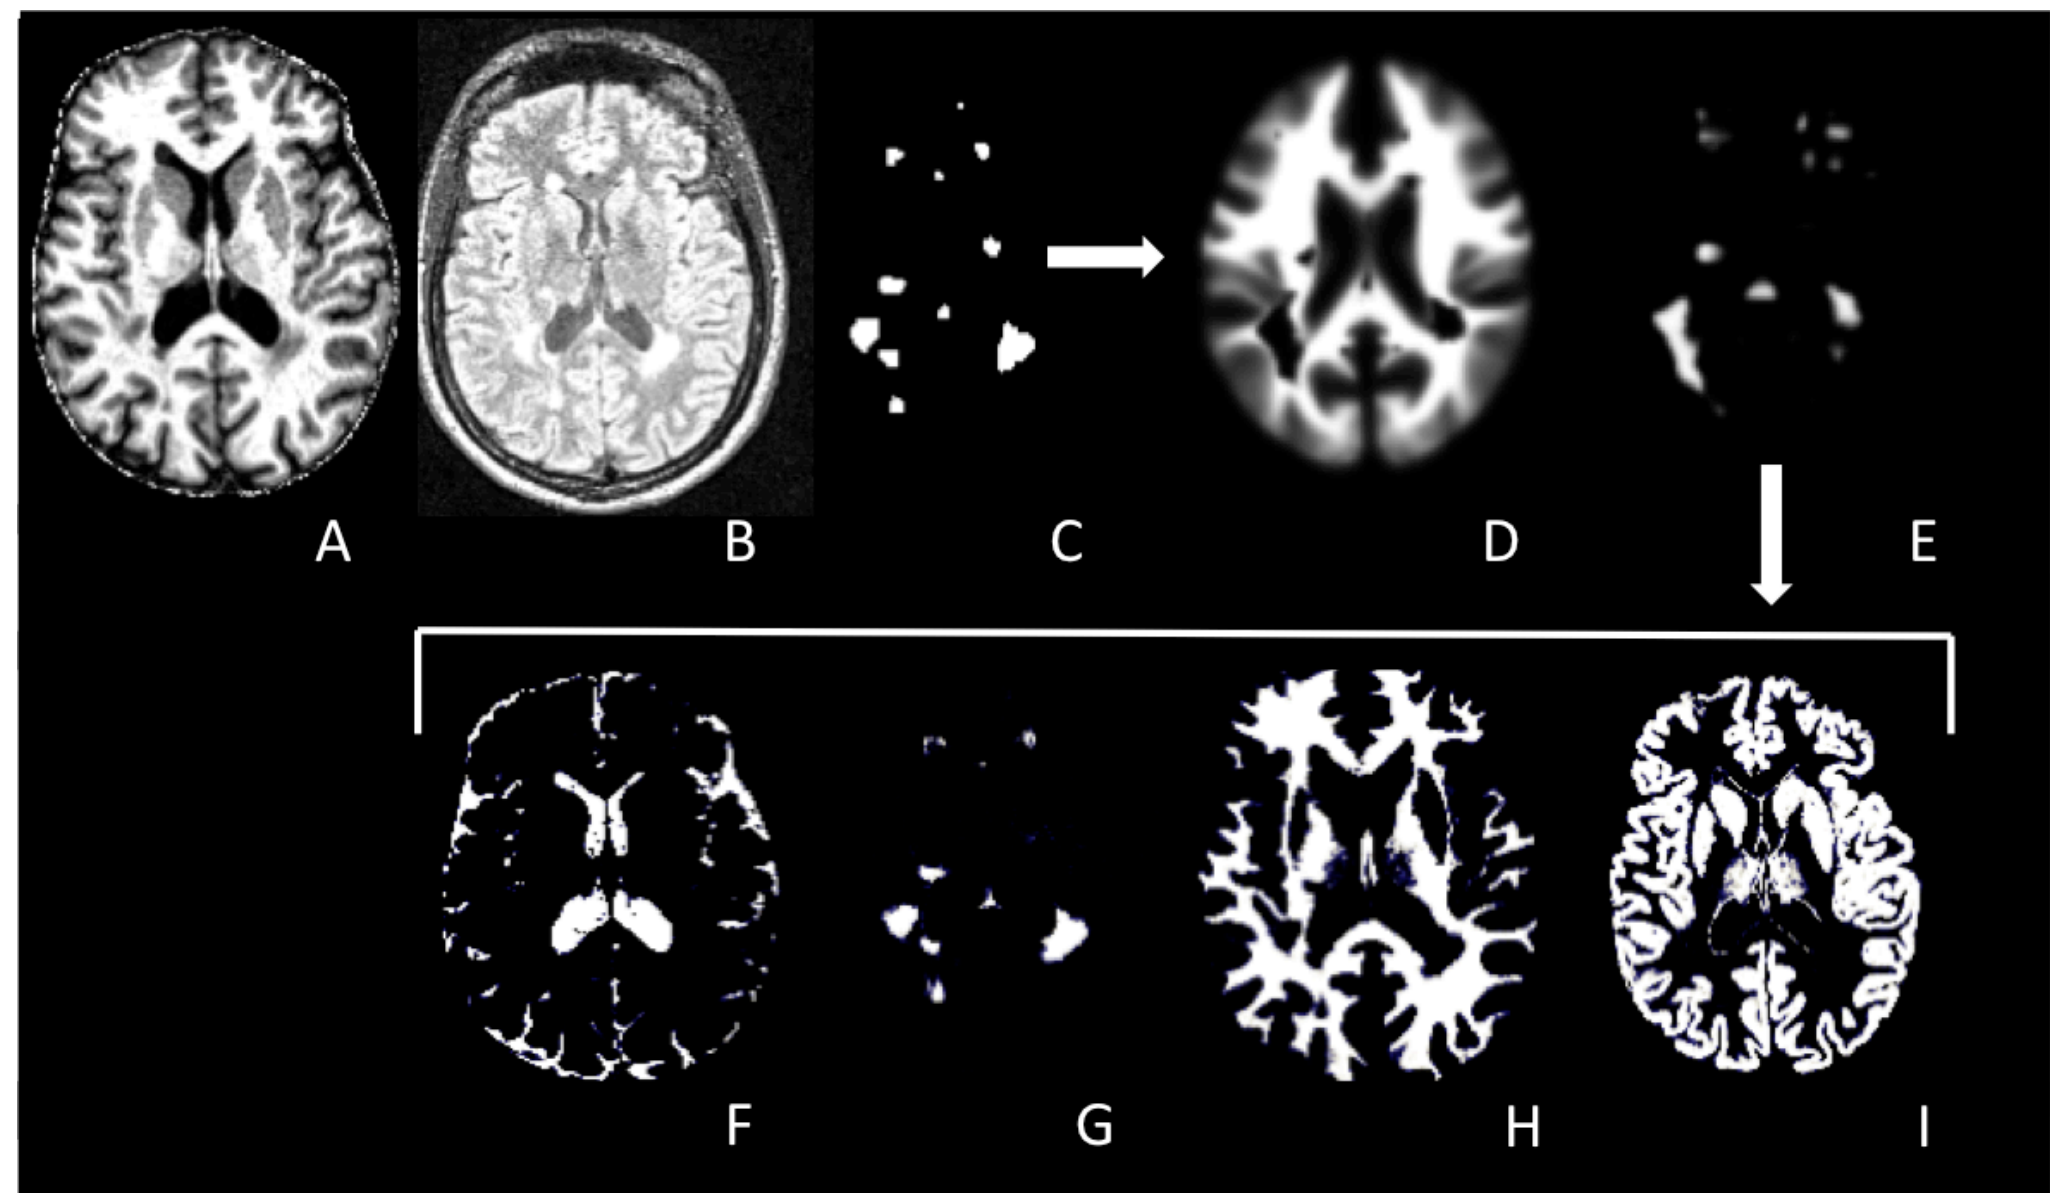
(A) MT MR imaging; (B) FLAIR 3D; (C) binary lesion mask; (D, E) updated WM and lesion TPM's; (F-I) a posteriori probability maps (CSF, lesion, white & gray matter) resulting of unified segmentation of MR images.
